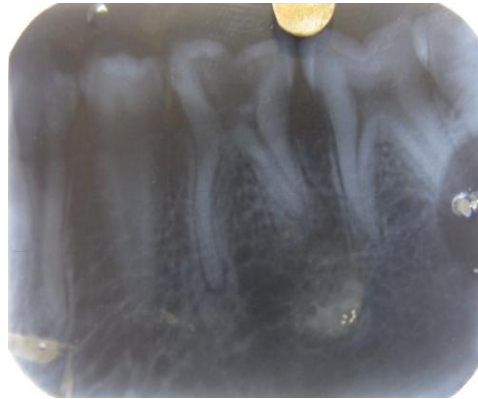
Preoperative radiograph showing double distal root outline suggesting the presence of an RE in mandibular right first molar
